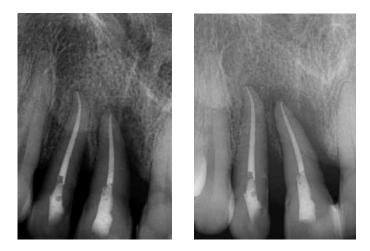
Teeth Nos. 7 and 8 after I&D and curettage, sealant is removed. Mesial No. 7 calculus was removed after this X-ray was taken (left). Figure 10: Healing at 9 months post endodontic therapy and periodontal treatment with some bone regeneration and periapical healing (right)
